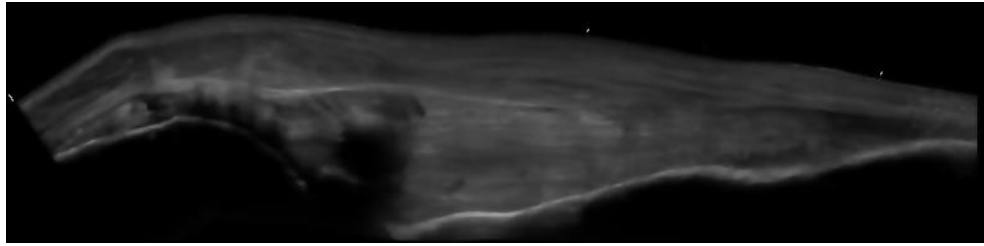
Cadaver musculoskeletal ultrasound image after applying ADF.
